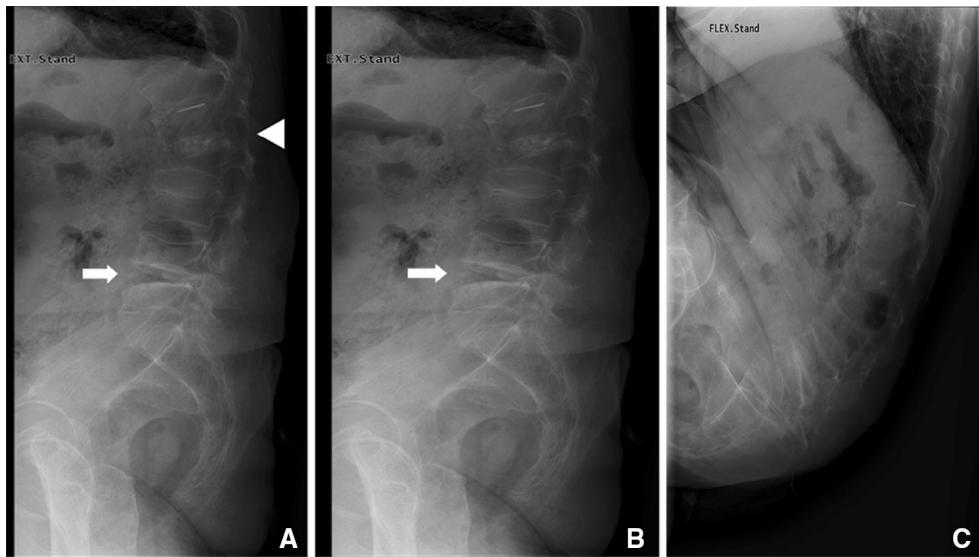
a The upright plain radiograph showed local thoracolumbar kyphosis with losing of lumbar lordosis (white arrowhead) and significant widening of the L4–L5 intervertebral space (white arrow)
